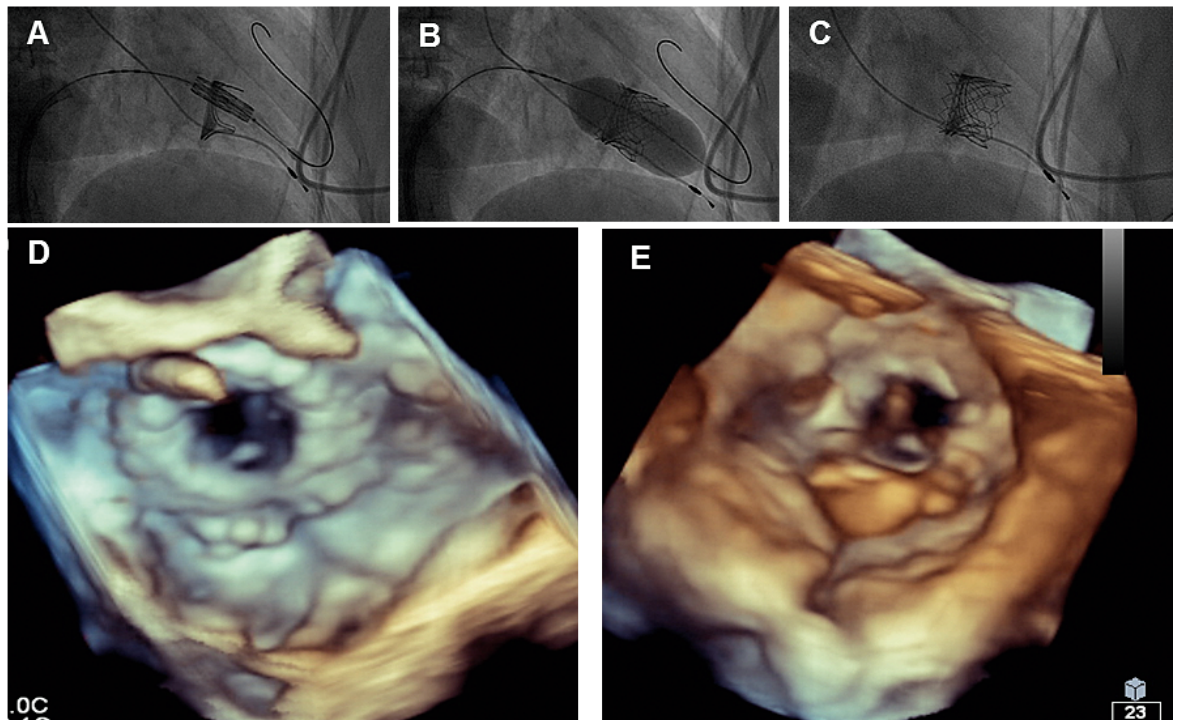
Valve-in-valve procedure at the tricuspid position. (A) Fluoroscopic image of tricuspid valve-in-valve procedure using Edwards Sapien valve with transeptal approach. (B) Fluoroscopic image during deployment Edwards Sapien valve in surgical bioprosthetic valve. (C) Fluoroscopic image after valve-in-valve procedure using Edwards Sapien valve. (D,E) Three-dimensional transoesophageal echocardiography of patient with tricuspid valve in valve after failure of a surgical bioprosthetic valve implantation from the right atrium (D) and from the right ventricle (E).
